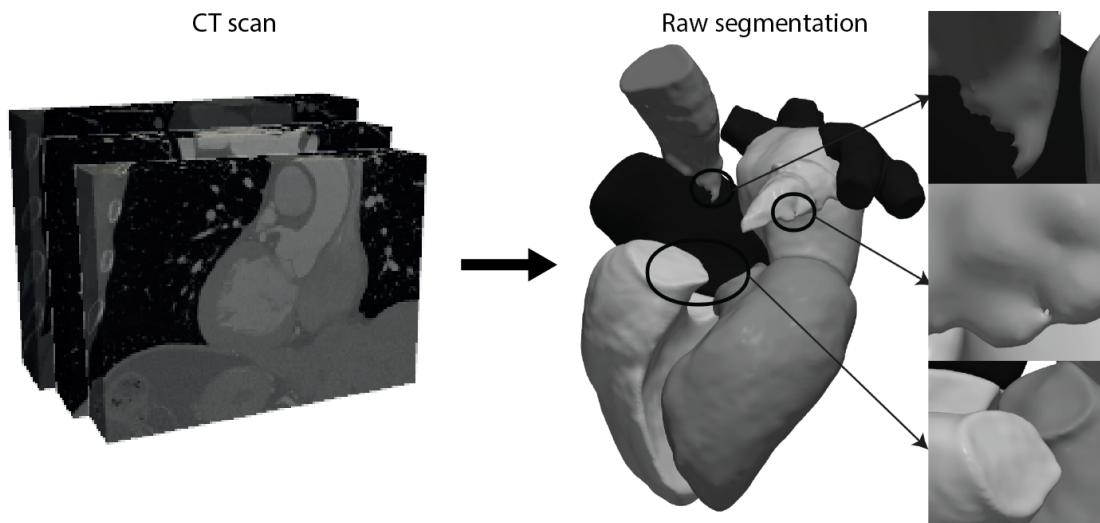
CT scan data (left) and corresponding raw segmented cardiac anatomy (right). The zoomed view on the right highlights typical segmentation artifacts: manual delineation leads to small holes and poor connectivity between neighboring anatomical structures, particularly in junctional regions.
